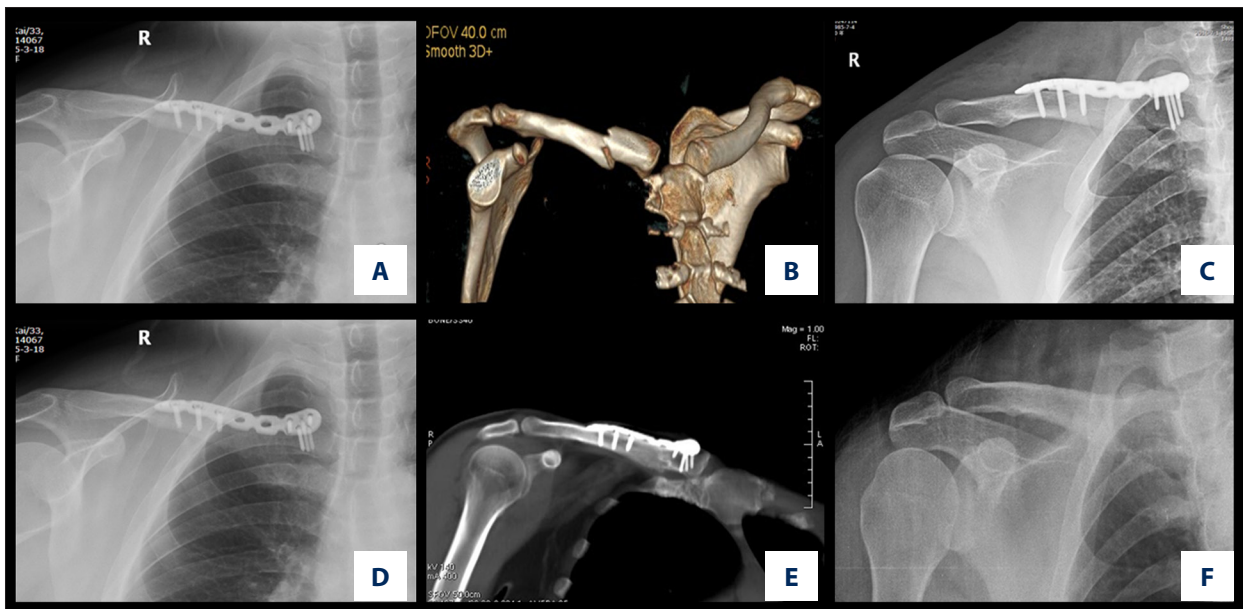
A 33-year-old male was diagnosed of a medial clavicle fracture. (A) X-ray of the clavicle after operation. (B) Computed tomography image of the medial clavicle fracture. (C) X-ray after treatment by locking plate. (D, E) The fracture healed after 1-year post operation. (F) The fixation was removed.
